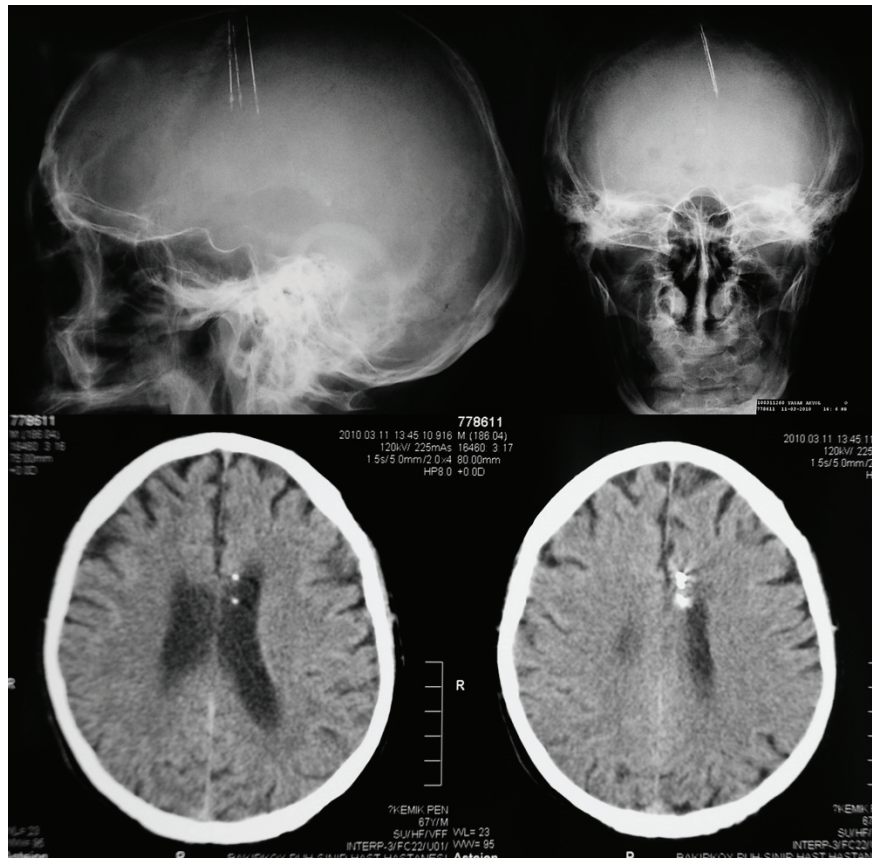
A 62-year-old man. A plain X-ray of the skull and cranial computed tomography show three sewing needles extending from the frontal convexity into the left lateral ventricle.
